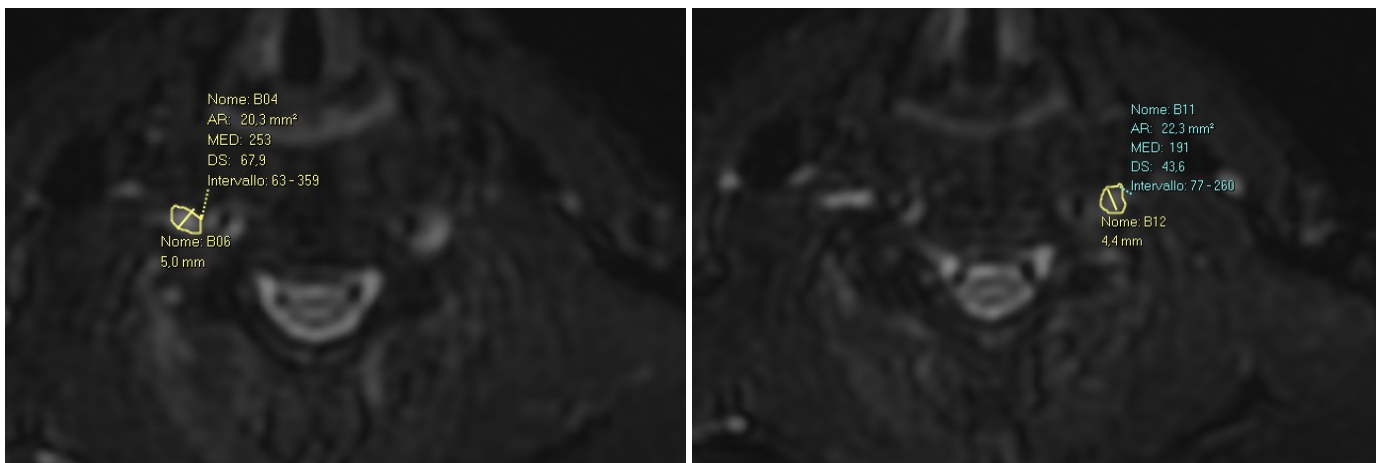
Axial images from MRI in 3D Cube Nerves, with quantitative measurements of the nerve roots to analyze in CSA and T2-weighted intensity signal (AR and MED). In this case, the observed measurements combined the CSA (mm) = 5.0 mm with the AR and MED measurements.
